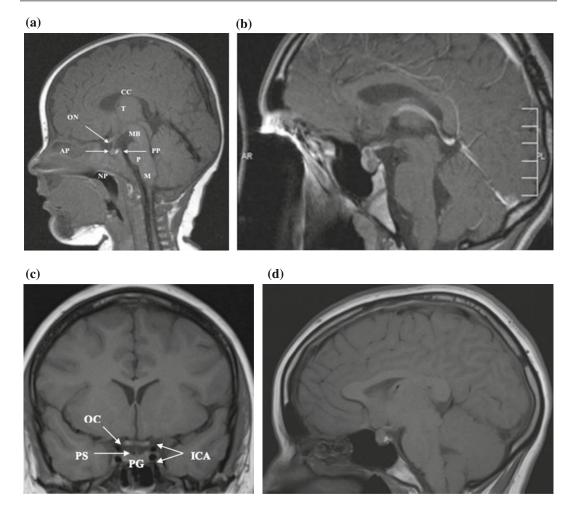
a Midline sagittal section of brain MRI depicting the gross anatomical relations of anterior pituitary in a 2.5 year old infant. b Midline sagittal section of brain MRI in an adolescent male with Rathke's pouch cyst abutting the optic chiasm. c Coronal section of brain MRI at the level of pituitary. d Midline sagittal section of brain MRI in an adolescent female with enlarged pituitary gland. The gland appears to be moulding the optic chiasm. Follow-up MRI after
